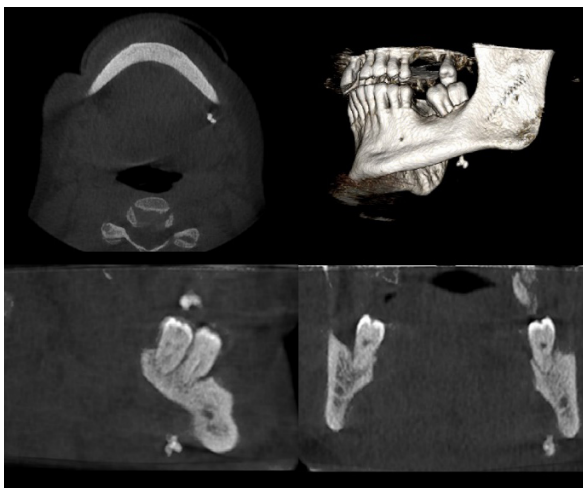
CBCT images of a sialolith in the left submandibular region.
